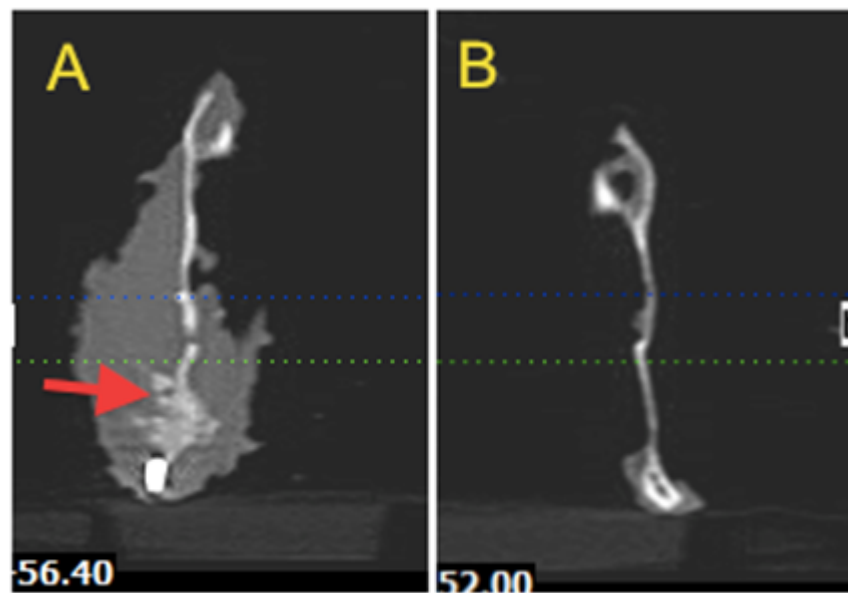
Coronal sections of the CBCT scans through the ramus of the mandible for case 240; A) shows the area of bone regeneration (red arrow). B) Shows the contralateral side, the thickness of the slices is 2 mm.
